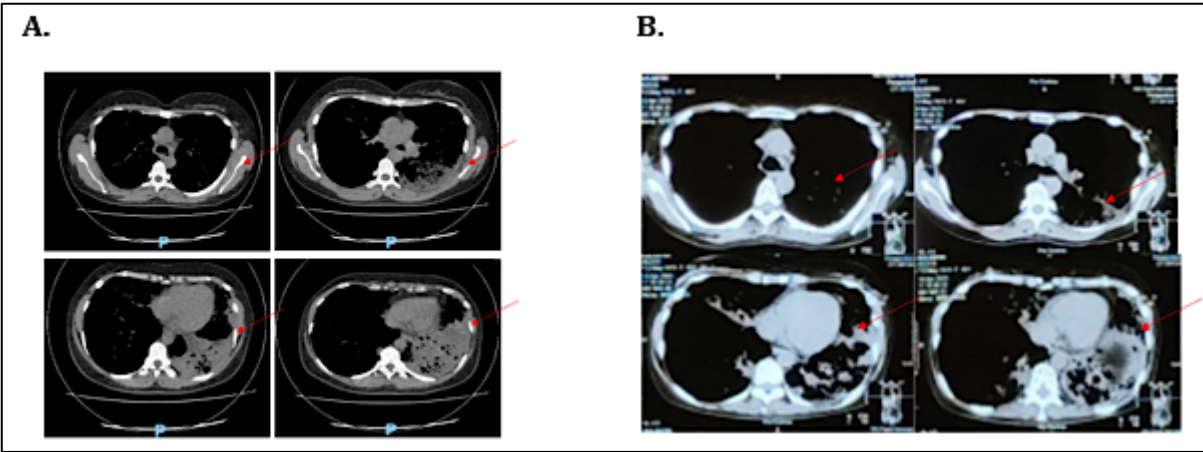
Thoracic CT Findings Demonstrating Bronchiectasis and ILD-Like Abnormalities. (A) Chest CT obtained on 10 January 2025 showing extensive bilateral cystic bronchiectasis, ground-glass opacities with mosaic attenuation, centrilobular nodules forming a tree-in-bud pattern, areas of consolidation and honeycombing-like cystic clustering predominantly involving the left lower lobe, raising suspicion for concurrent fibrotic interstitial lung disease, (B) Chest CT obtained on 14 April 2025 demonstrating persistent bilateral bronchiectatic changes with signet-ring appearance, multiple cystic lesions, pulmonary nodules, secondary infectious changes and persistent left pleural effusion
